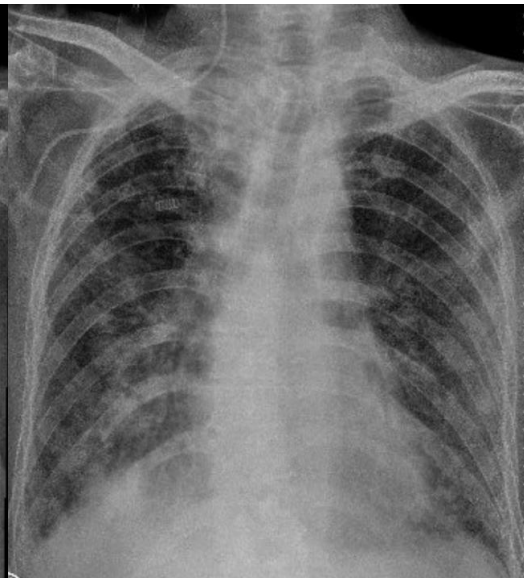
Chest X-Ray (71st Day)
